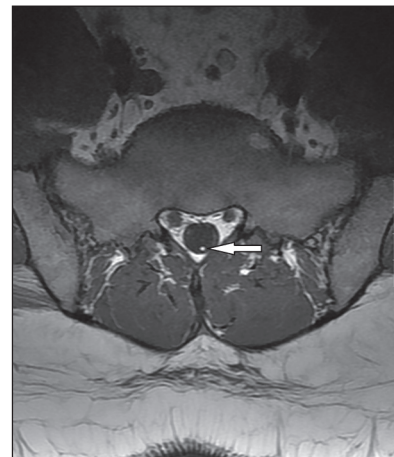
Axial T1 weighted MRI image demonstrating FFT as a hyperintense intrathecal dot like structure in patient 2
